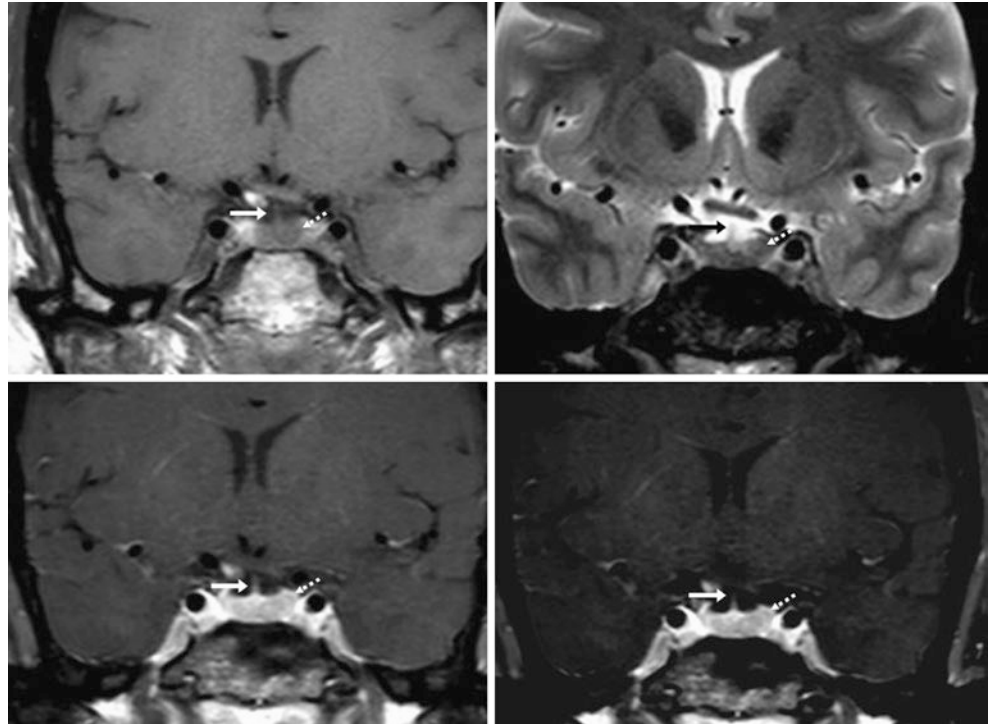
The patient was a 20-year-old female with a history of vasculitis (no pituitary symptoms). A 1.5 T MRI depicted a midline infundibulum (*arrows*), but there was asymmetry of the lobes (*); the right
